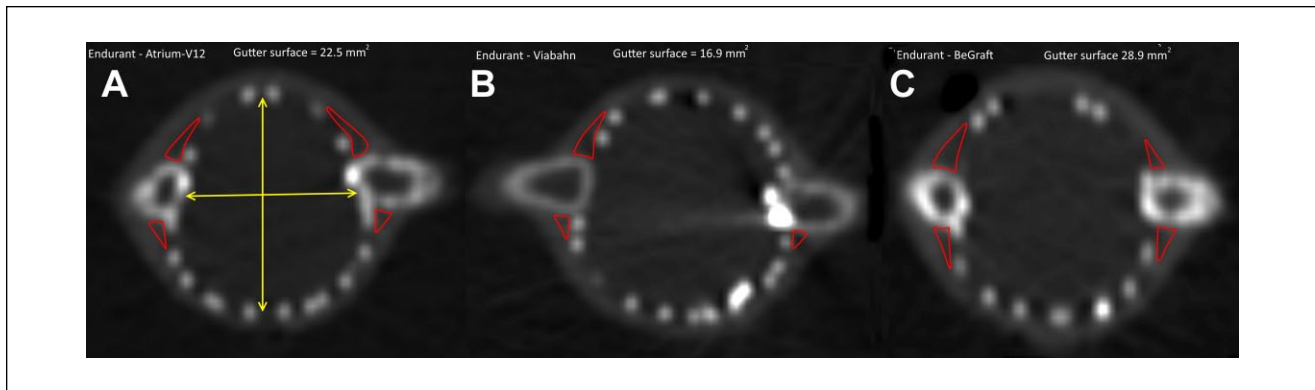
Computed tomography (CT) slices at the midline of the right renal artery perpendicular to the central lumen line for measurement of the gutter surfaces in the (A) Endurant-Advanta, (B) Endurant-Viabahn, and (C) Endurant-BeGraft configurations.
